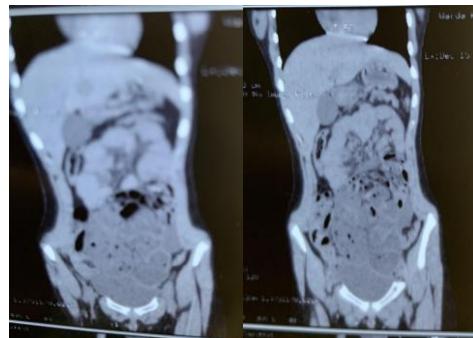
CT scan of abdomen (Sagittal section) showed clustered, dilated small bowel loops.
